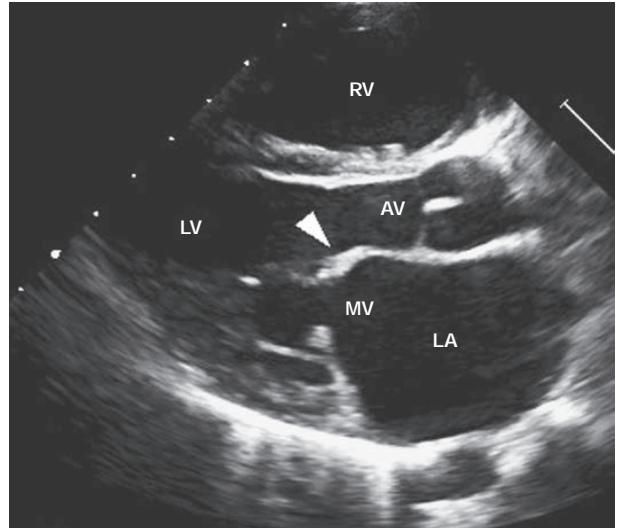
Transthoracic echocardiographic image from a 5-year-old boy with chronic rheumatic heart disease. This diastolic image demonstrates leaflet thickening, restriction of the anterior mitral valve leaflet tip and doming of the body of the leaflet toward the interventricular septum. This appearance (marked by the arrowhead) is commonly described as a “hockey stick” or an “elbow” deformity. AV, aortic valve; LA, left atrium; LV, left ventricle; MV, mitral valve; RV, right ventricle. (Courtesy of Dr. Bo Remenyi, Department of Paediatric and Congenital Cardiac Services, Starship Children’s Hospital, Auckland, New Zealand.)
